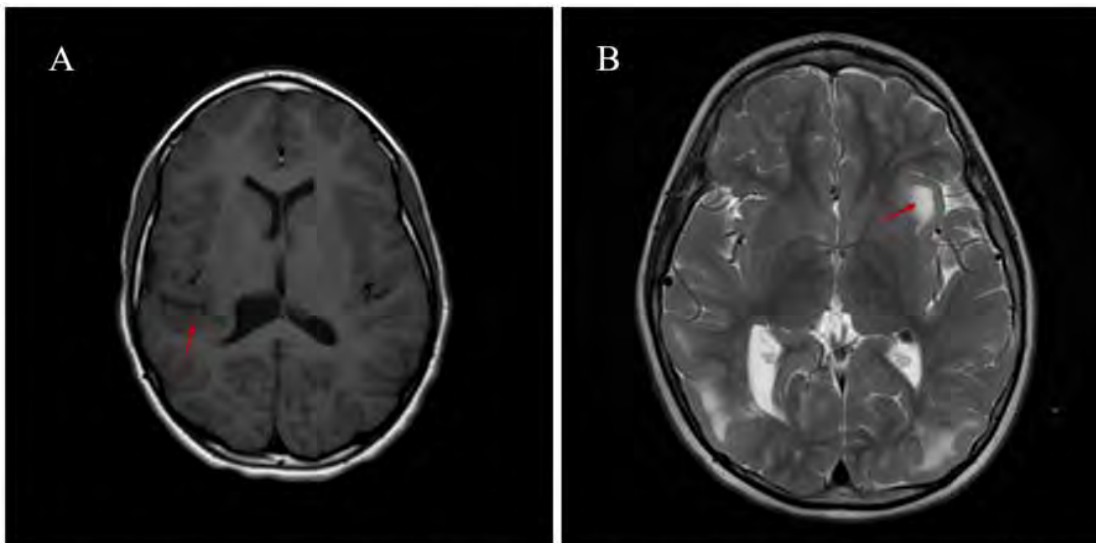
(A) on axial T1 MRI, a tract of irregular, thickened gray matter is seen extending from the cortical surface to the occipital horn of the right lateral ventricle (arrow) with dimpling on the surface of the right lateral ventricle consistent with closed lip type schizencephaly; (B) on axial T2 MRI of a pediatric patient with tuberous sclerosis, a hyperintense cortical tuber is seen in the left perisylvian cortex (arrow).
